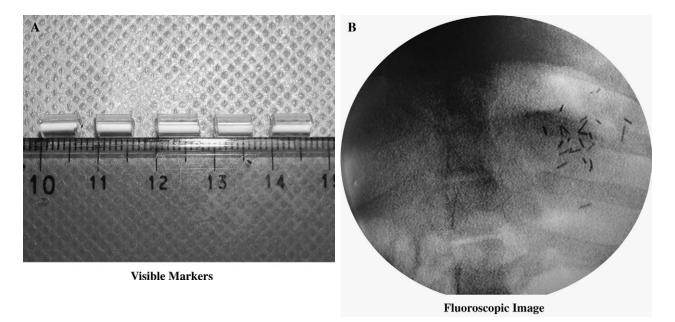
GI transit time was measured using (A) X-ray visible markers made from a nasogastric tube that was divided in 5–7 mm sections. (B) Twenty-four markers were confirmed by abdominal fluoroscopic imaging after placement into the stomach.
